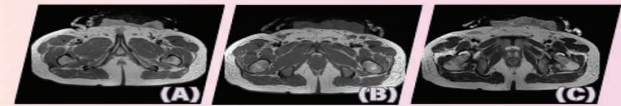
Preoperative Imaging Done - Abdominopelvic MRI (A) Axial on PD phase (B) Axial on T1 phase (C) Axial on T2 phase
